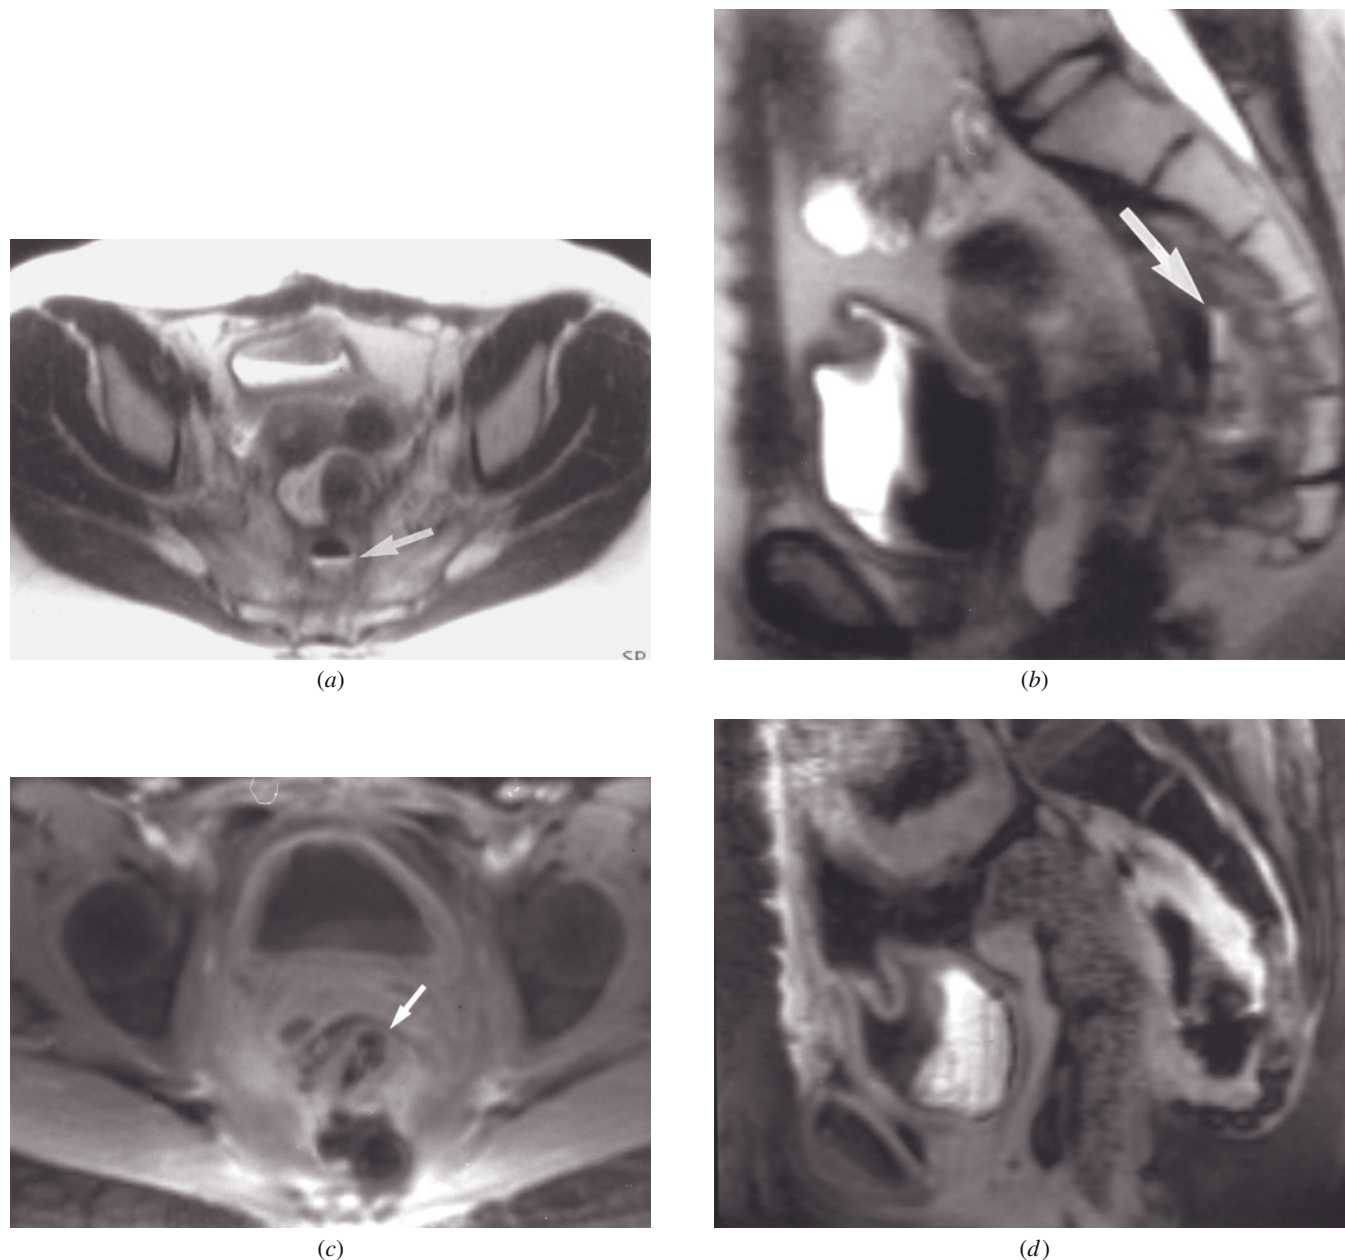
Rectal carcinoid recurrence associated with abscess. Transverse (*a*) and sagittal (*b*) postgadolinium T2-weighted SS-ETSE and transverse (*c*) and sagittal (*d*) interstitial-phase gadolinium-enhanced T1-weighted SGE fat-suppressed images. There is thickening and enhancement of the rectal wall (arrow, *c*) associated with soft tissue stranding within the pelvis. An air-fluid level is present in the presacral space (arrow, *a, b*), consistent with a small abscess.
